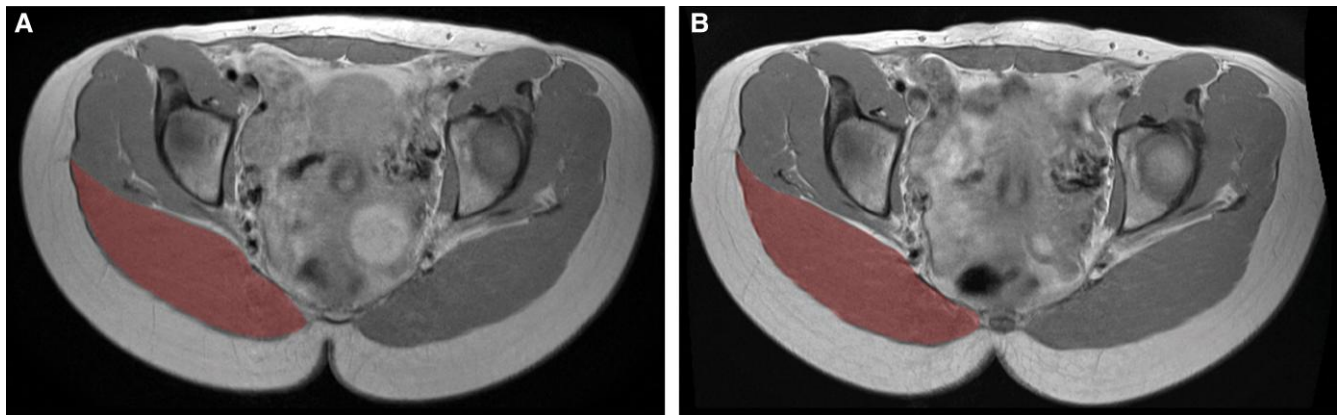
The MRI scan of the 21-year-old female from Figure 3, MRI scans taken (A) at baseline and (B) at 3-month follow-up. The highlighted part represents the changes that occurred in gluteus maximus (red) during the study. Reproduced with permission from BTL Industries.
